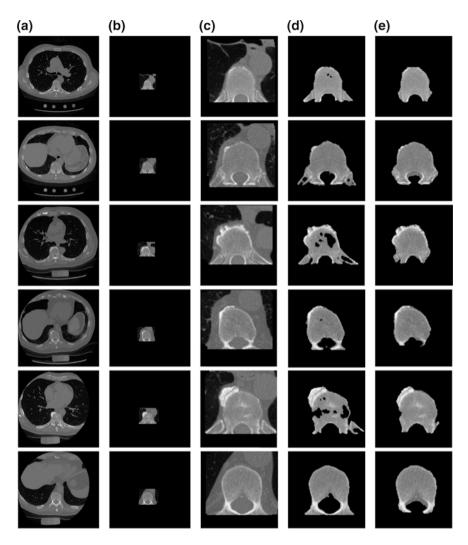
An example of the initial labeling. a Original CT images. b Detection of the VB region and refinement. c The cropped VB region. d The initial labeling, f^* using only the intensity and spatial interaction models. e The final segmentation using three models
